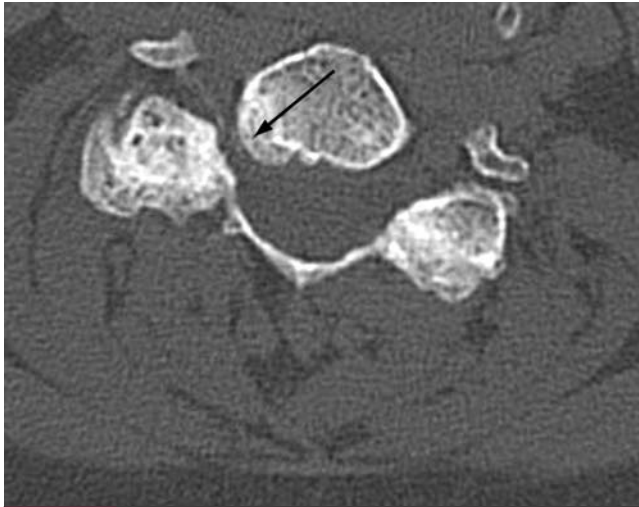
Axial CT of the cervical spine showing foraminal stenosis (arrow).
